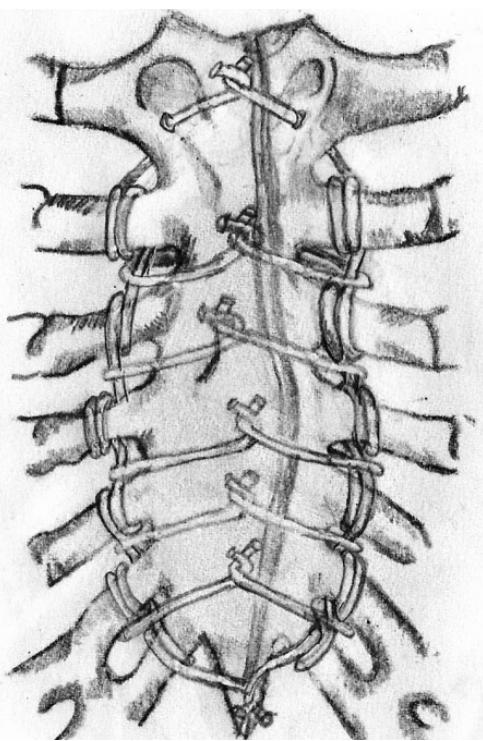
Free ends of parasternal wires were caudally and cranially tightened along with circumferential wires.
